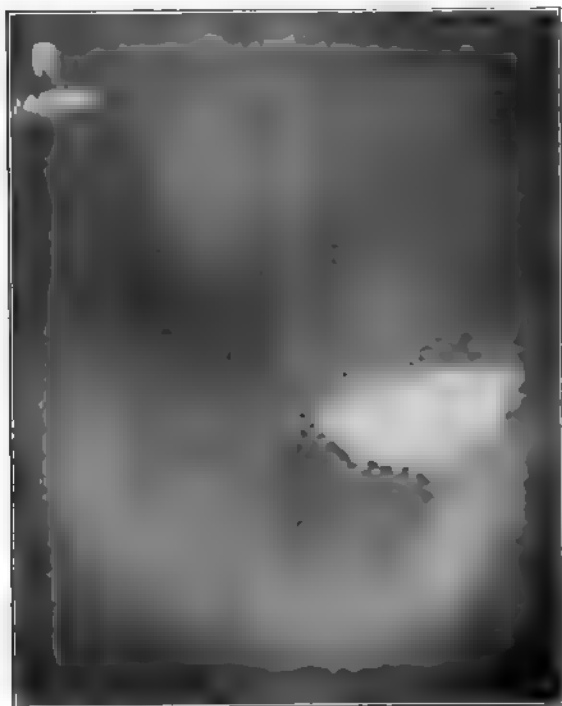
(Case No. A90,500; X-ray No. 34,236.) Residue after six hours.
